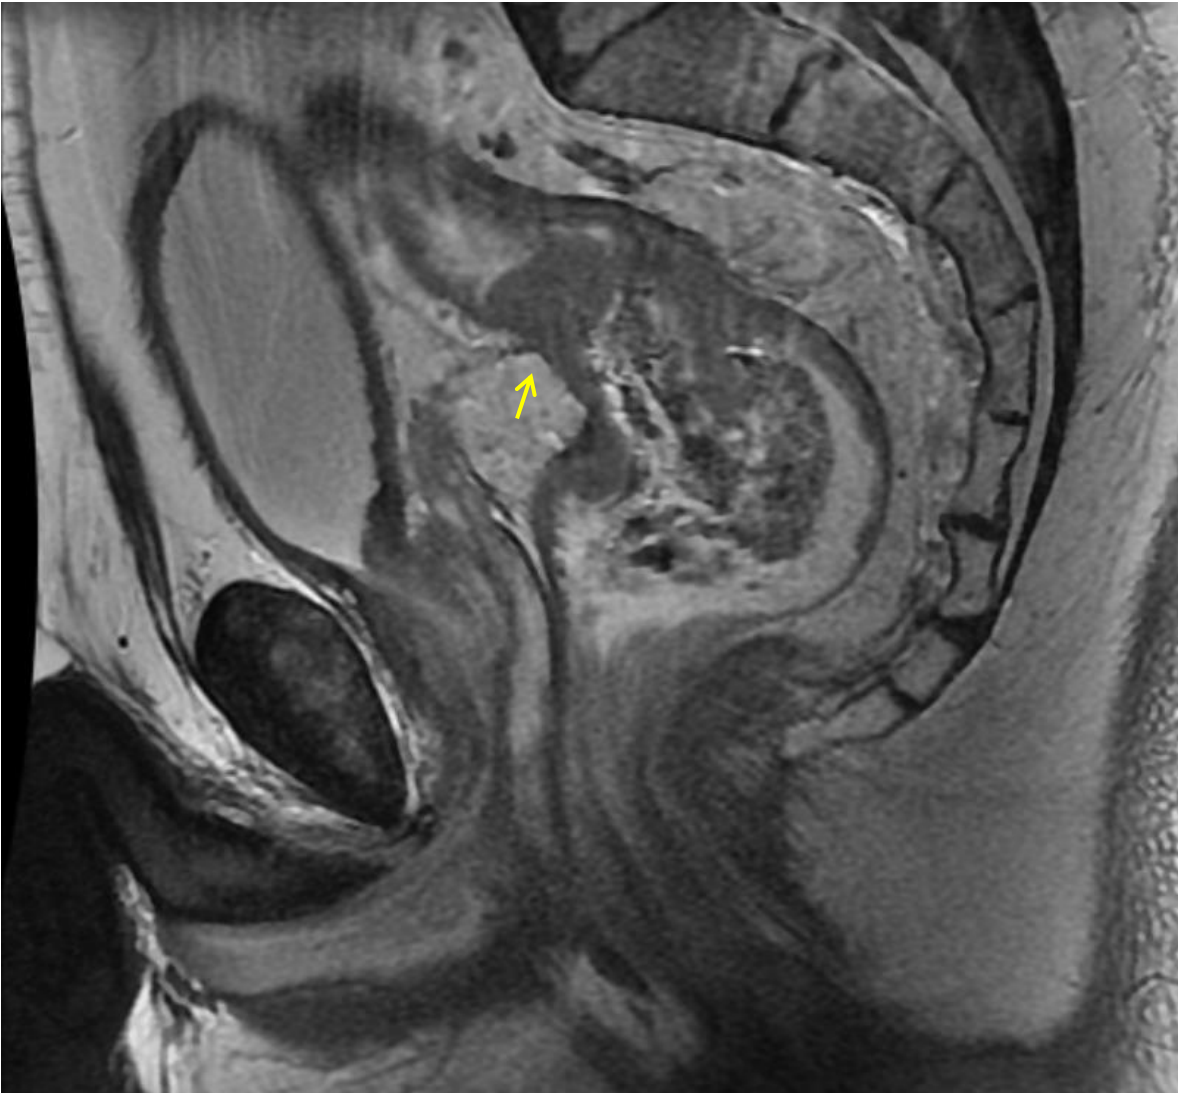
(Case 201) Sagittal MRI images of the same 56-year old male patient with a locally advanced staged cT4aN1b, secondary to infiltration of the peritoneal reflexion (yellow arrow)
